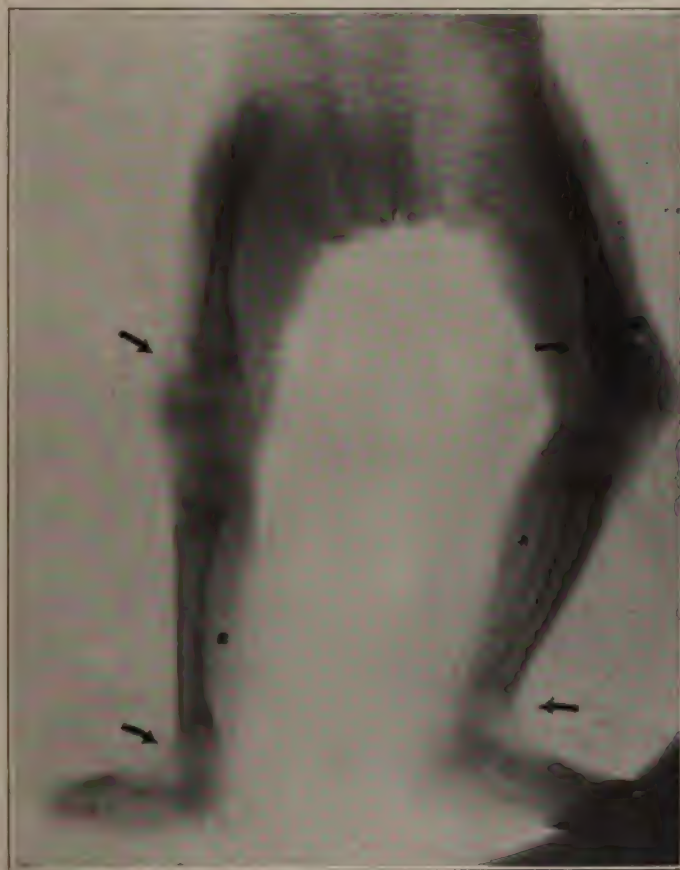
Rontgenogram of the Lower Extremities of a Child Showing Marked Changes in the Epiphyses and Multiple Fractures Marked by x's. (X-ray Dept. J. H. H.)
